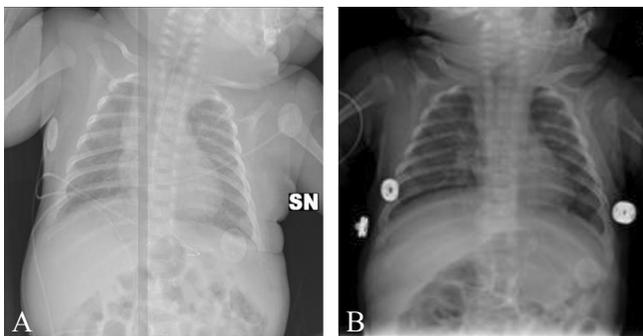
Chest X-ray showing the lung interstitial involvement before (A) and after 3 weeks (B) of treatment with PEP-mask.
